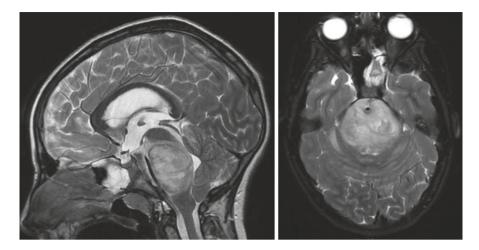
Diffuse intrinsic pontine glioma: Sagittal and axial T2 MRI showing a DIPG and hydrocephalus in a 10-year-old. A shunt was placed
